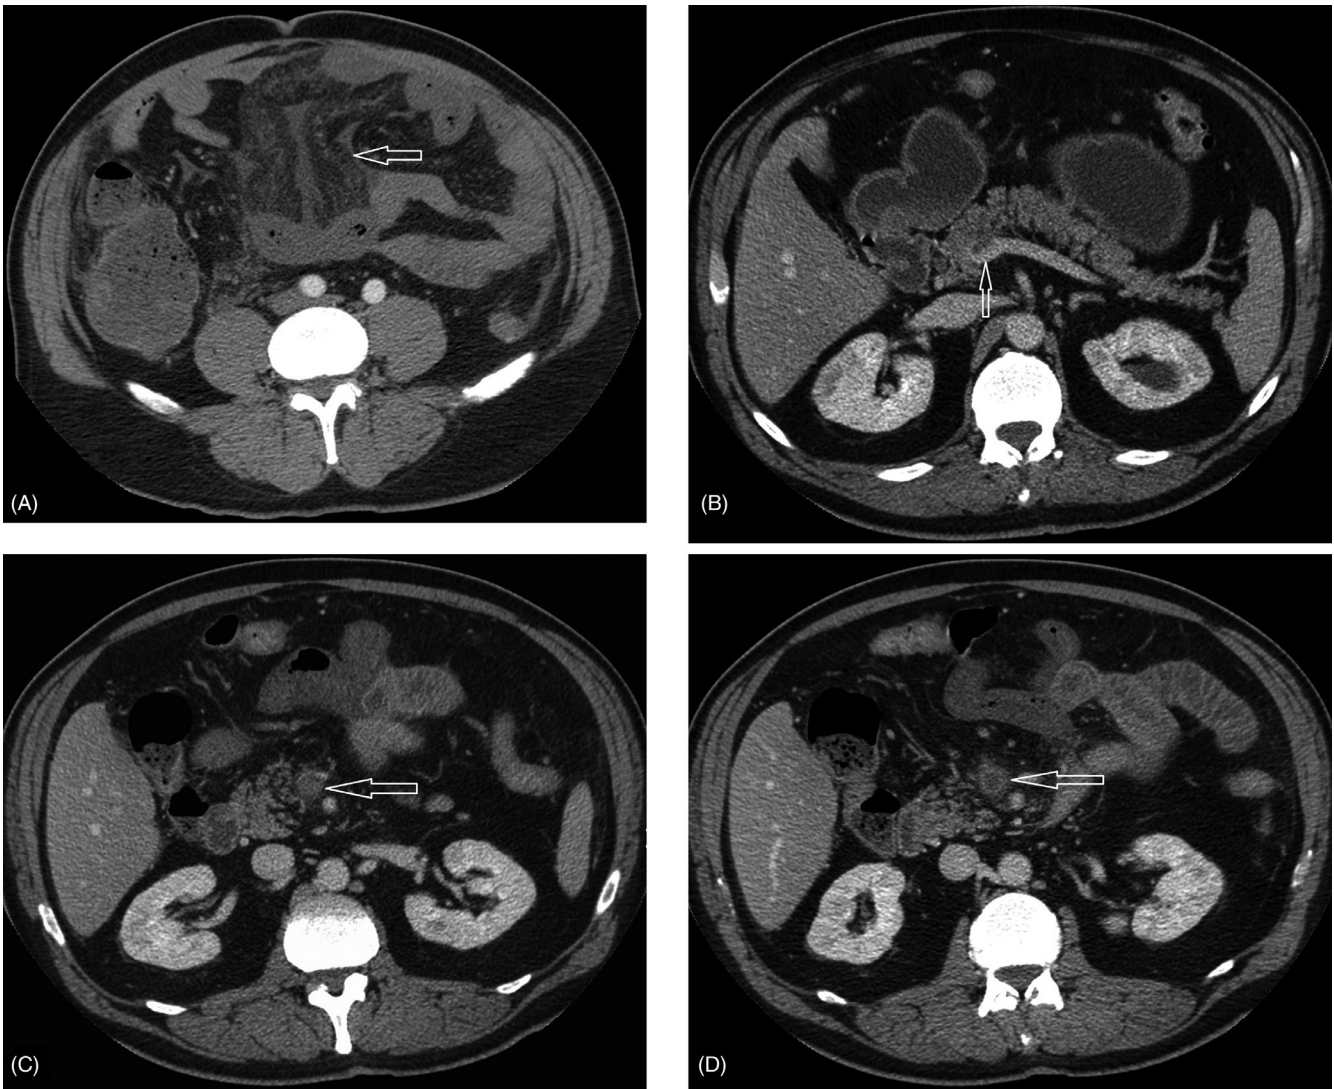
Contrast-enhanced computed tomography (CT) of a 55-year-old male patient with superior mesenteric vein thrombosis. (A) Contrast-enhanced CT showing an ischemic ileal loop with wall thickening, initial pneumatosis of the wall, and adjacent free liquid (white arrow). (B) Extension of the thrombosis to the confluence of the superior mesenteric vein with the splenic and portal veins (white arrow). (C and D) Thrombosis of the superior mesenteric vein with a filling defect during venous phase contrast-enhanced CT (white arrow).
